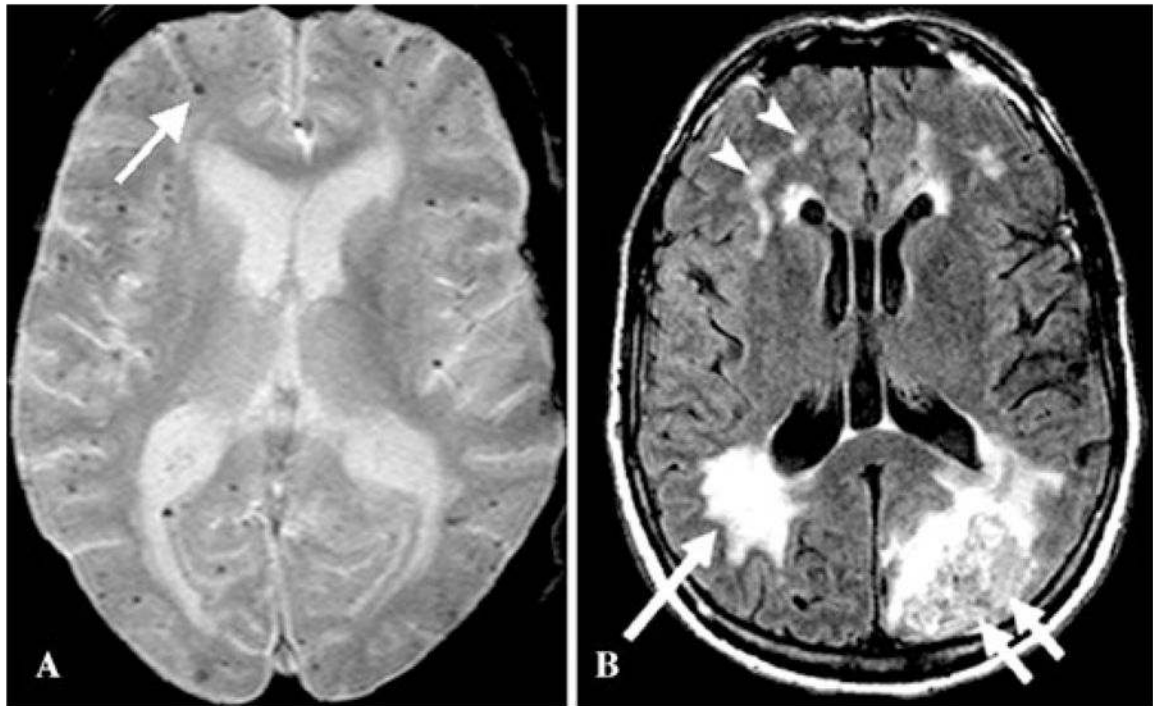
MRI in the axial plane in cerebral amyloid angiopathy. (A) Gradient echo MRI demonstrating multiple punctate areas of hemorrhage (microbleeds, *arrow*) at the cortico-subcortical junctions. (B) MRI FLAIR sequence in a patient with lobar intraparenchymal hemorrhage in the left occipital lobe (*double arrows*), as well as periventricular WMH (*single arrow*) and subcortical WMH (*arrowheads*).²²¹
